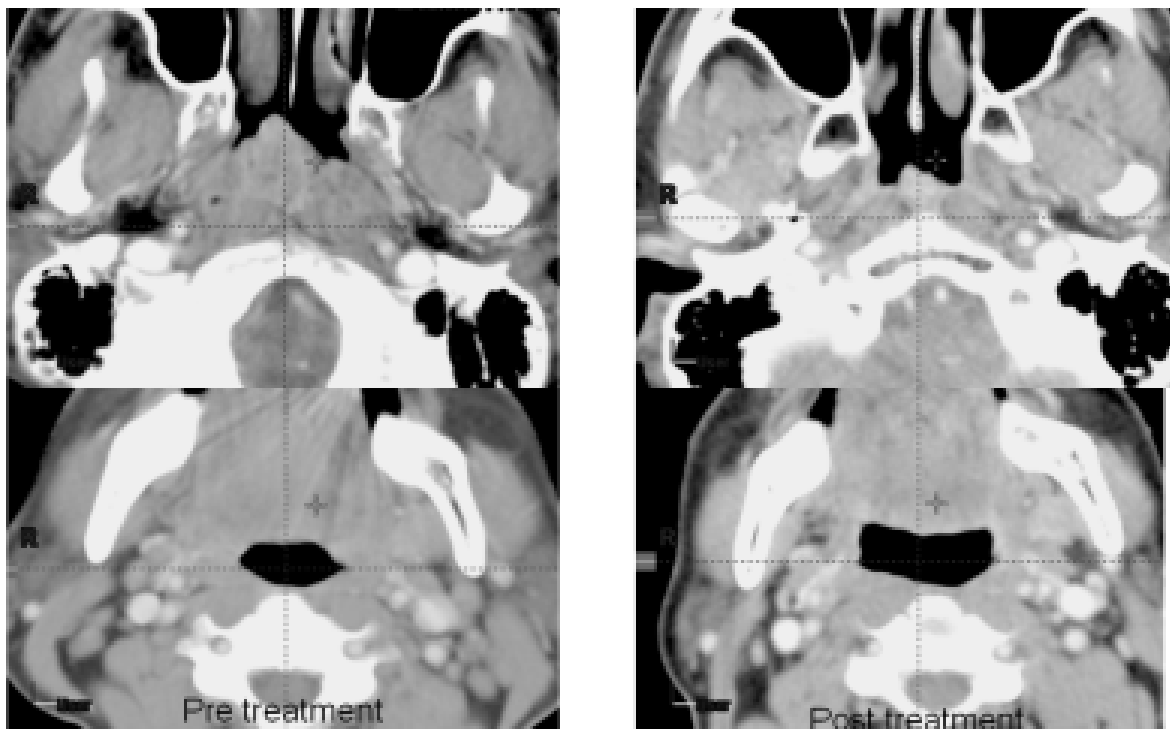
A comparison of pre and post treatment CT images at the level of nasopharynx and lymph nodes
